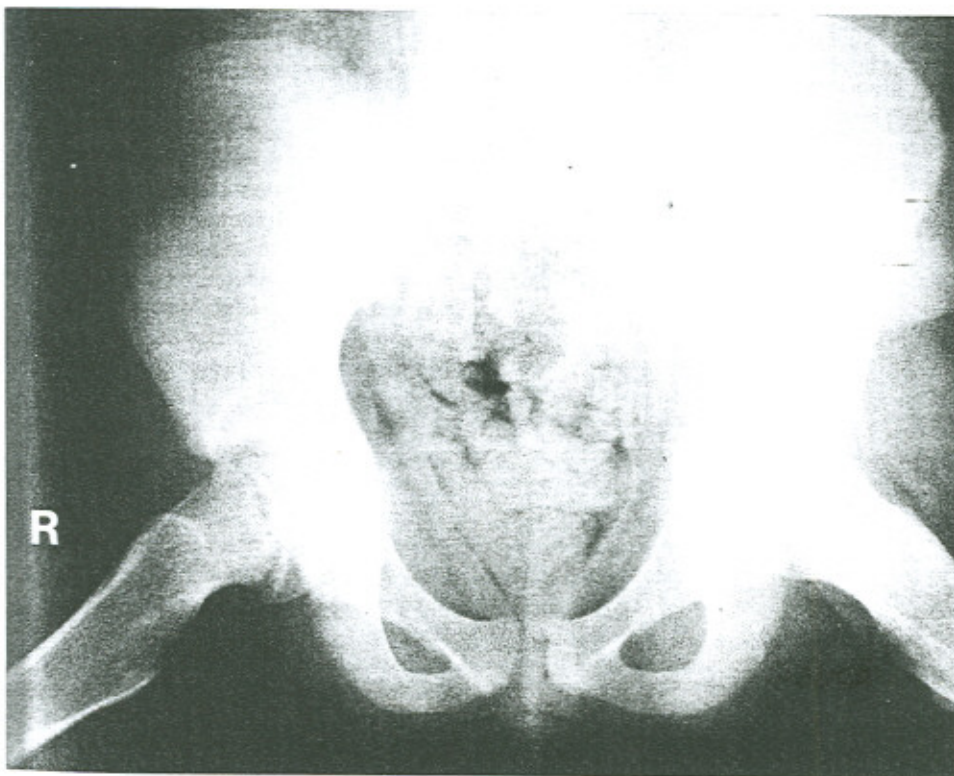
The frog-leg view taken one month after the initial radiograph reveals a posteromedial slip of the right femoral capital epiphysis.
